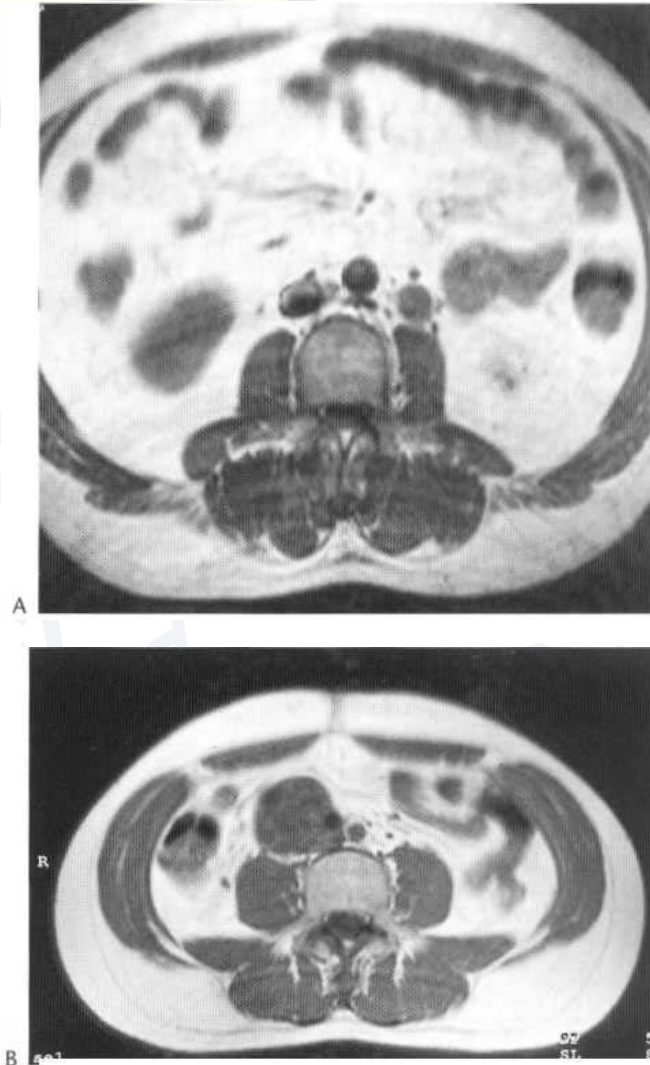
Transverse T_1 -weighted MR images on two different patients. (A) In this case there is a solitary left para-aortic lymph node tumour deposit from a left-sided testicular primary. (B) In this case there is a more substantial right-sided deposit from a NSGCT showing considerable heterogeneity. It has encased and displaced the inferior vena cava.
